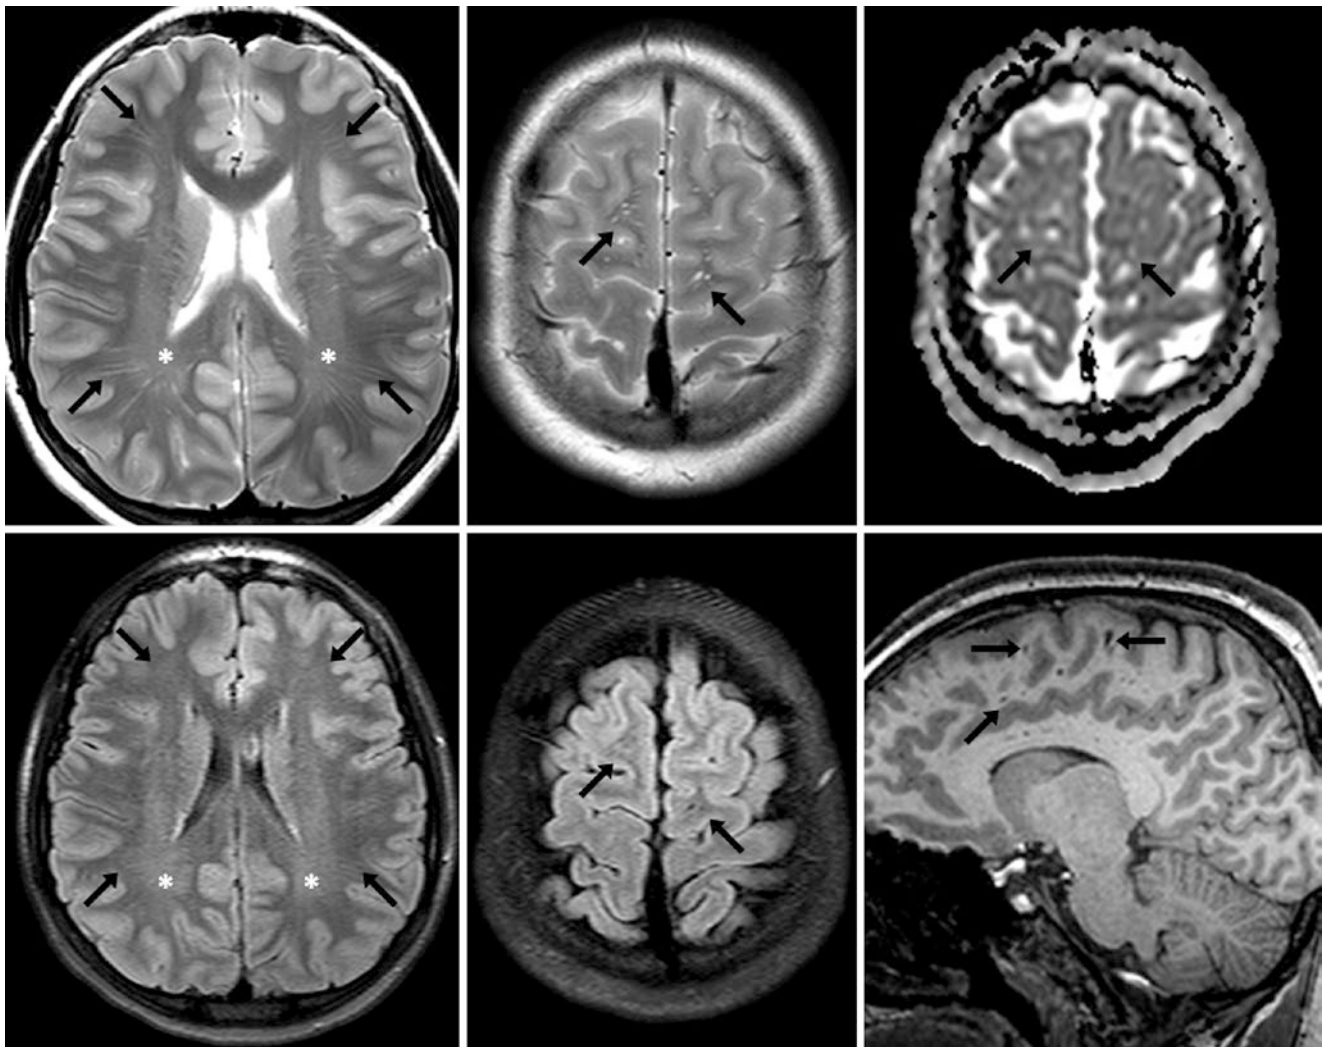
A 13 year old had mildly dilated PVSs throughout the subcortical white matter (*arrows*) on 3T MRI axial T2WIs (*top, left two images*), being nearly invisible on FLAIR (*bottom, left two images*). These appear to radiate from the lateral ventricles and corpus callosum. Axial
